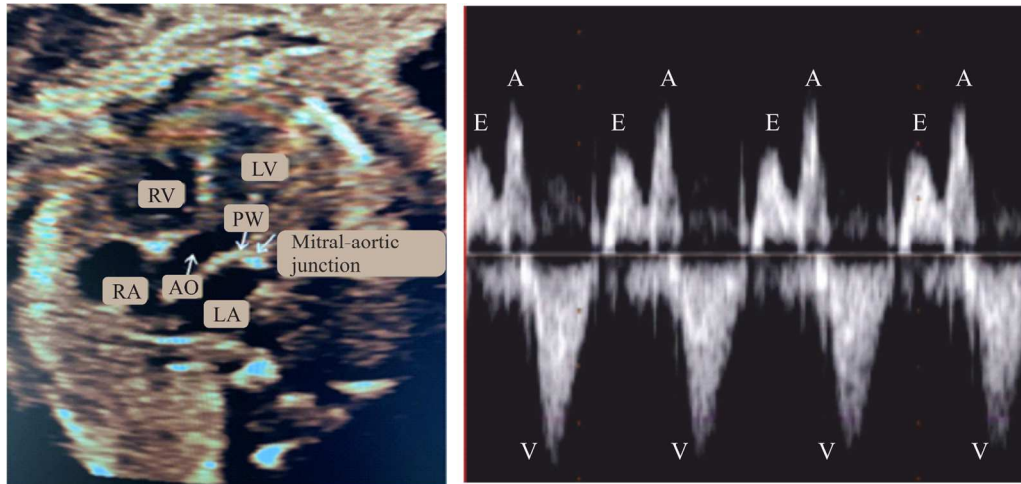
An apical five-chamber view of a foetal heart (on the left) along with an example of PWD velocity trace with the characteristic waveform (on the right) reflecting the mitral inflow due to the passive filling of the LV and atrial contraction (i.e., the E and A peaks, respectively) and the aortic outflow (i.e., the V peak) in different cardiac cycles. In the apical five-chamber view, the right and left ventricles (RV and LV, respectively), the left and right atria (LA and RA), the aortic region (AO) and the sample volume adopter for PWD acquisition (PW) are indicated. Adapted from [59].
